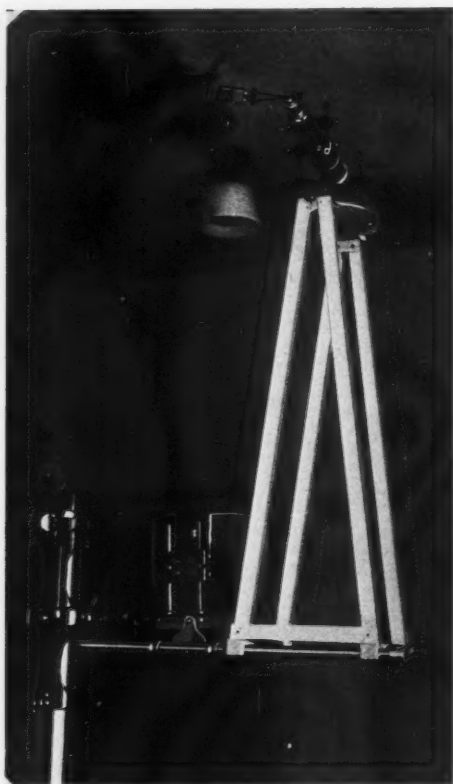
Showing device mounted upon the standard cross-arms swung out away from radiographic table, to allow the bed to be wheeled alongside the table beneath the tube. Note the wooden rod with hook over high tension wire to anode, which prevents spark jumping to near-by high tension tubular conductor. Also, note lead diaphragm and glass filter beneath tube stand of the device. The entire weight of the attachment is approximately four pounds. Base of device is firmly fastened to the cross-arms of tube stand by means of hook and eyes which are attached to the lower four corners of the device.
